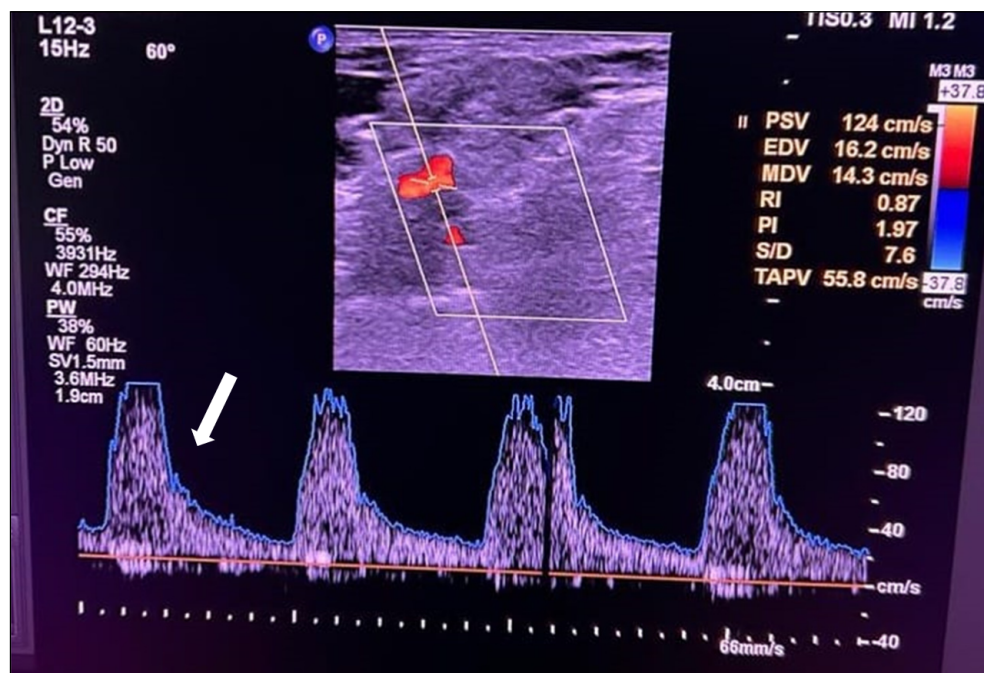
Ultrasound Doppler of left subclavian artery shows high peak velocity (white arrow).
